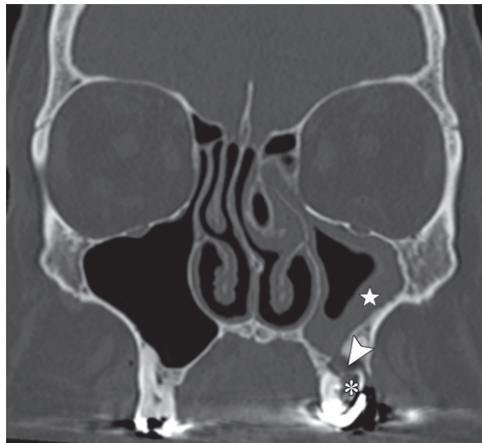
Odontogenic sinusitis. Coronal nonenhanced CT image (bone window) demonstrates unilateral maxillary sinusitis (☆) associated with a bone discontinuity that communicates the sinus floor with periodontal disease (arrowhead) around a tooth with a large carious lesion (*).
